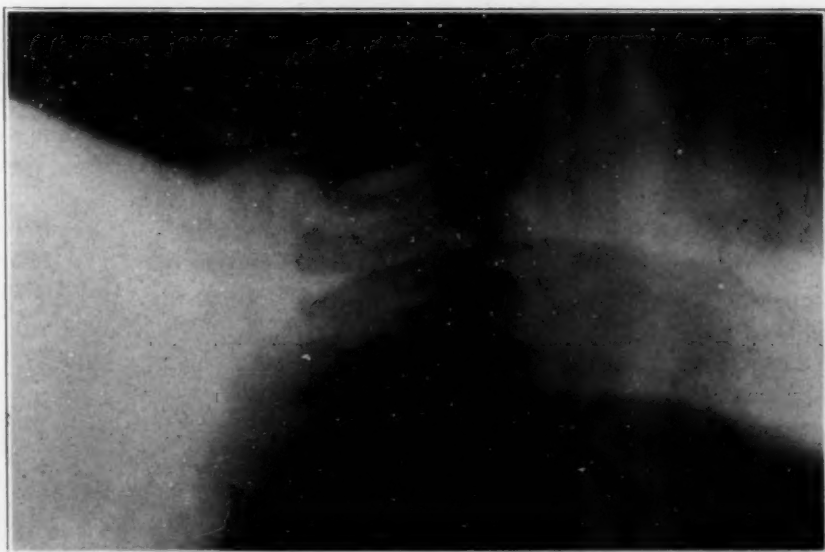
Roentgenogram of Case 25, cervical meningocele.
